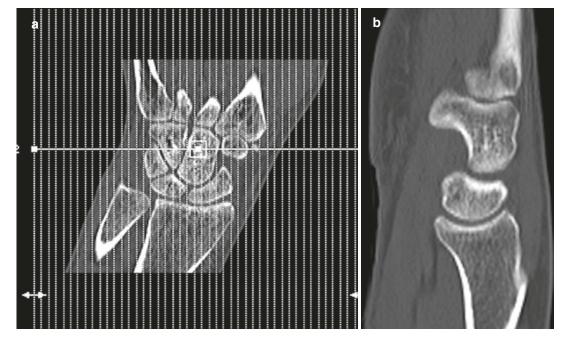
CT wrist (a) low-dose localizer image in coronal plane, similar to radiograph used as template to acquire images in correct planes with respect to anatomy.
